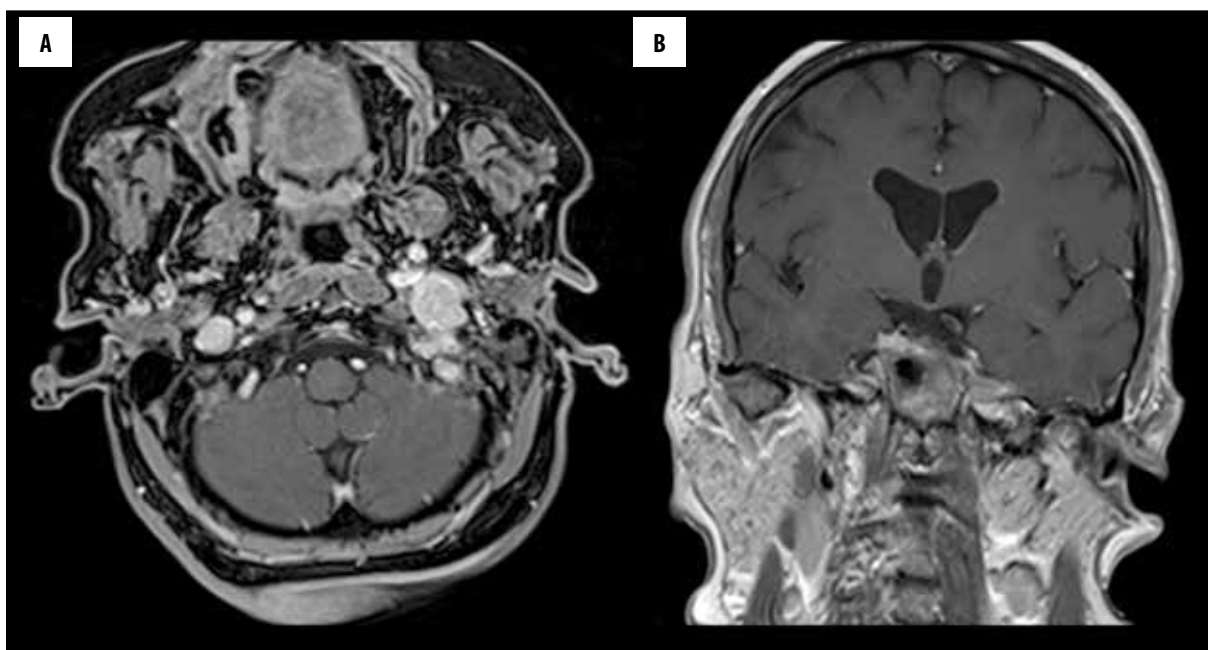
Axial (A) and coronal (B) T1+C magnetic resonance imaging sequences demonstrate a left-sided, homogeneously enhancing glomus jugulare tumor with a maximal diameter of 2.7 cm.
